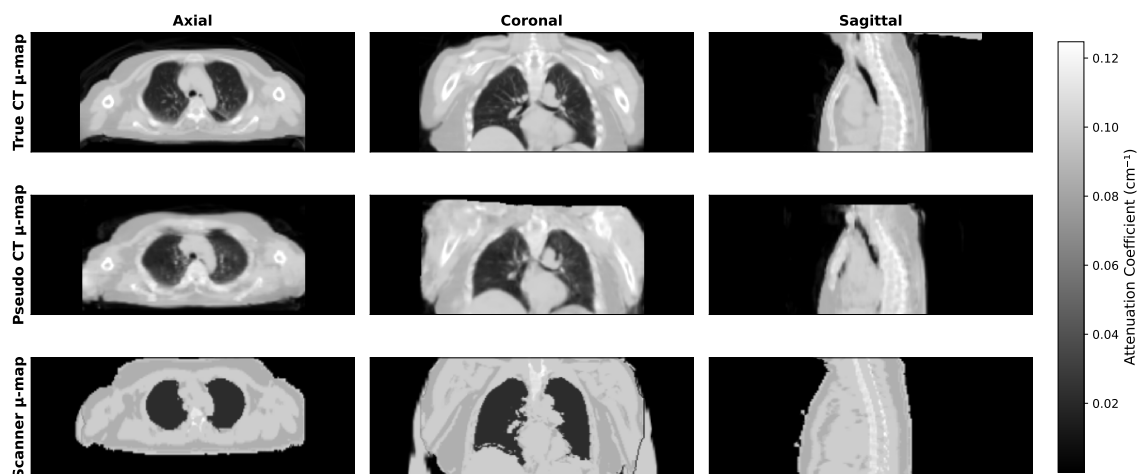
Comparison of attenuation maps (μ -maps; subject 011) used for PET/MR AC. The three rows show the true CT-based μ -map (top), pseudo CT-based μ -map generated using GAN-In (middle), and MR-AC μ -map (bottom). Each column represents different anatomical views: axial (left), coronal (center), and sagittal (right).
